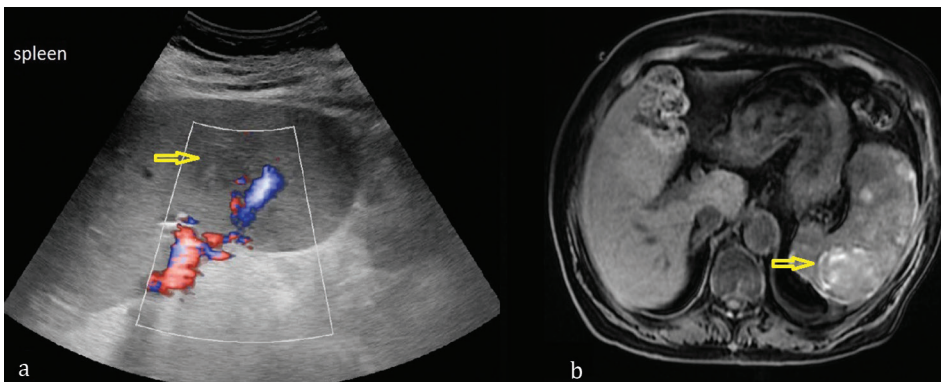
Splenic Gaucheroma: a) ultrasound imaging: multiple hypoechoic lesions, without Doppler signal and mass effect; b) MRI imaging: multiple calcified focal lesions.
